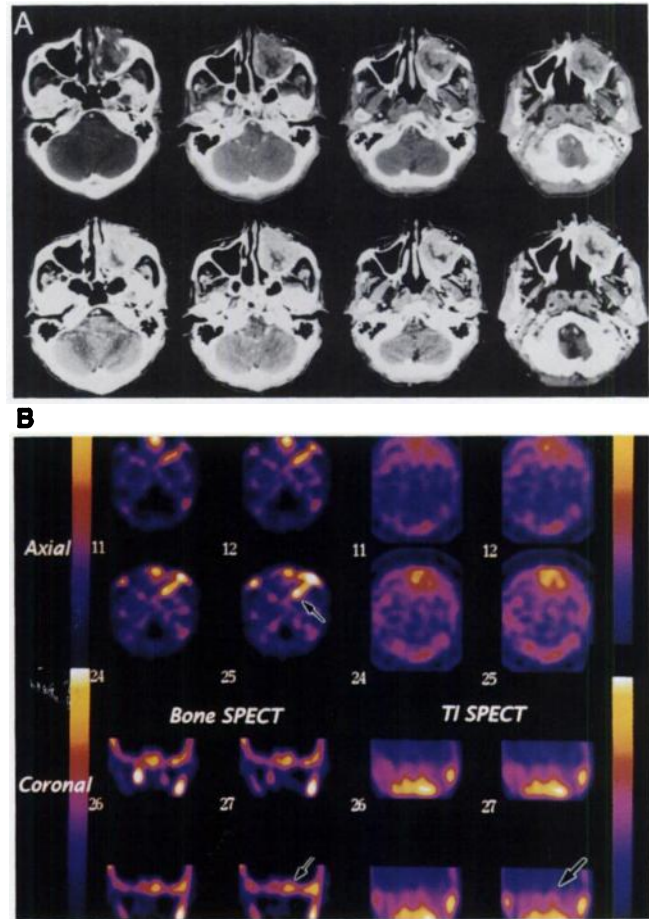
(A) CT scans (bone-window CT above, contrast-enhanced CT below) from a 66-yr-old man with maxillary cancer localized in the postero-lateral wall of the maxillary sinus are negative for skull-base invasion. (B) Bone SPECT revealed high accumulation in the skull base (small arrows); tumor SPECT was negative in this area (large arrow).
